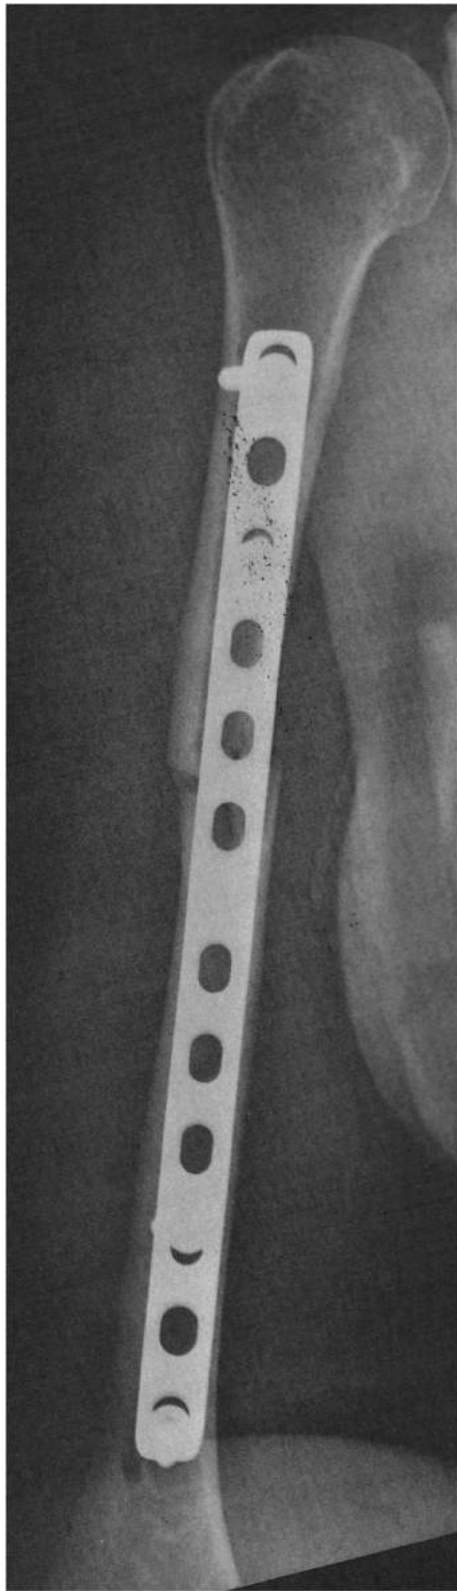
Postoperative radiography.
